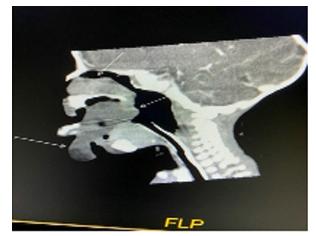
MRI showing soft tissue mass arising from right ethmoid, extending to nasopharynx and oral cavity
